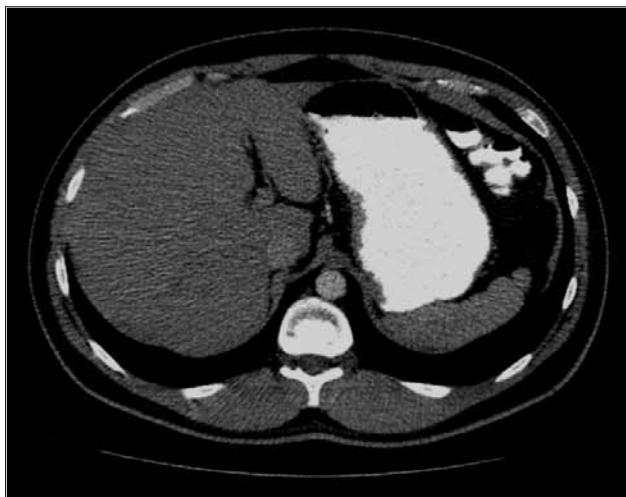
Significant regression is visible on axial contrast-enhanced CT compared to the hypodense nodular lesions observed in the anterior and posterior right lobes of Figure 1
